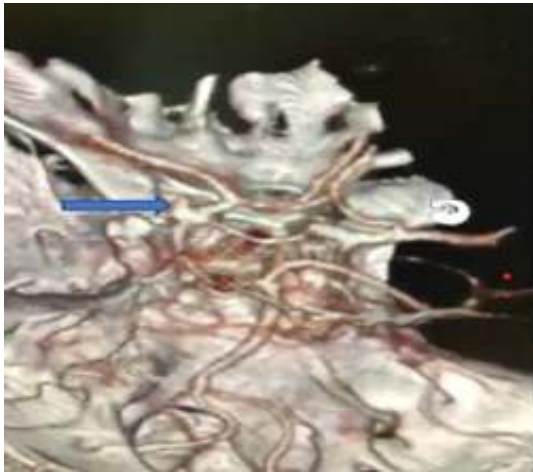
CT angiography shows an aneurysm at the ICA-Pcom junction (blue arrow).
